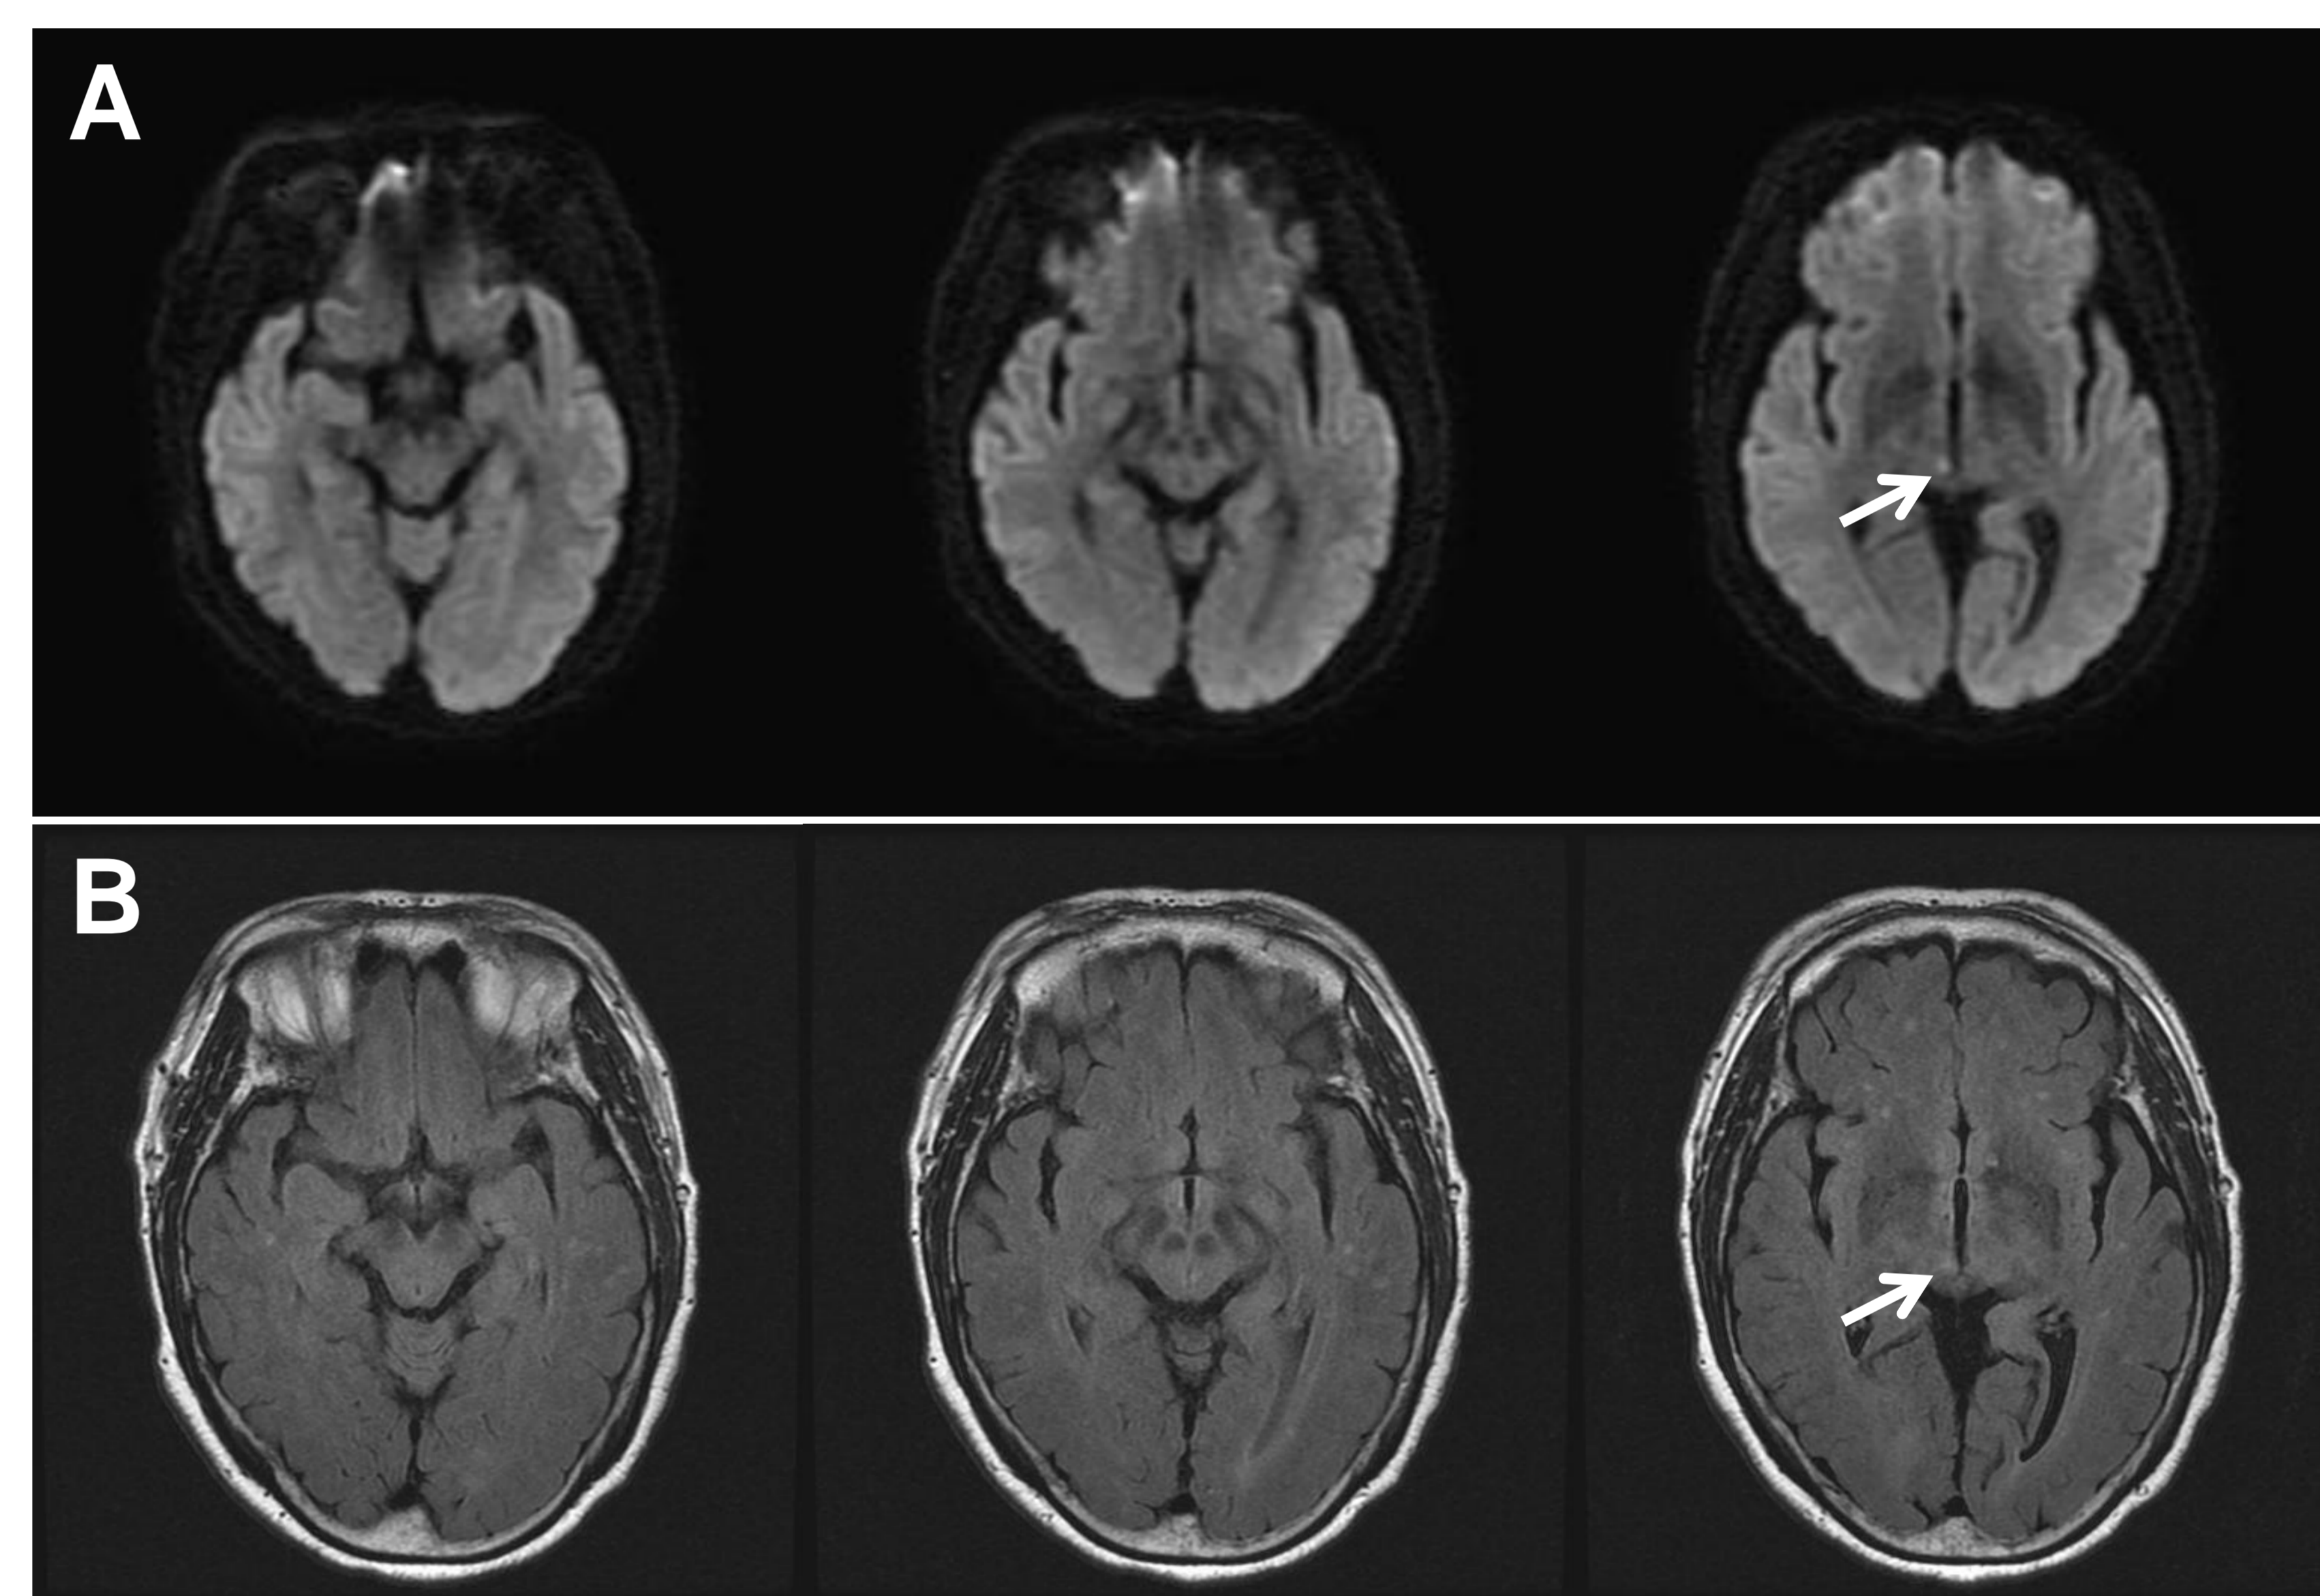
Brain MRI of the patient. Diffusion-weighted image (A) and fluid attenuated inversion recovery image (B) showed an acute ischemic infarct in the right medial thalamus (arrows) without midbrain involvement.
